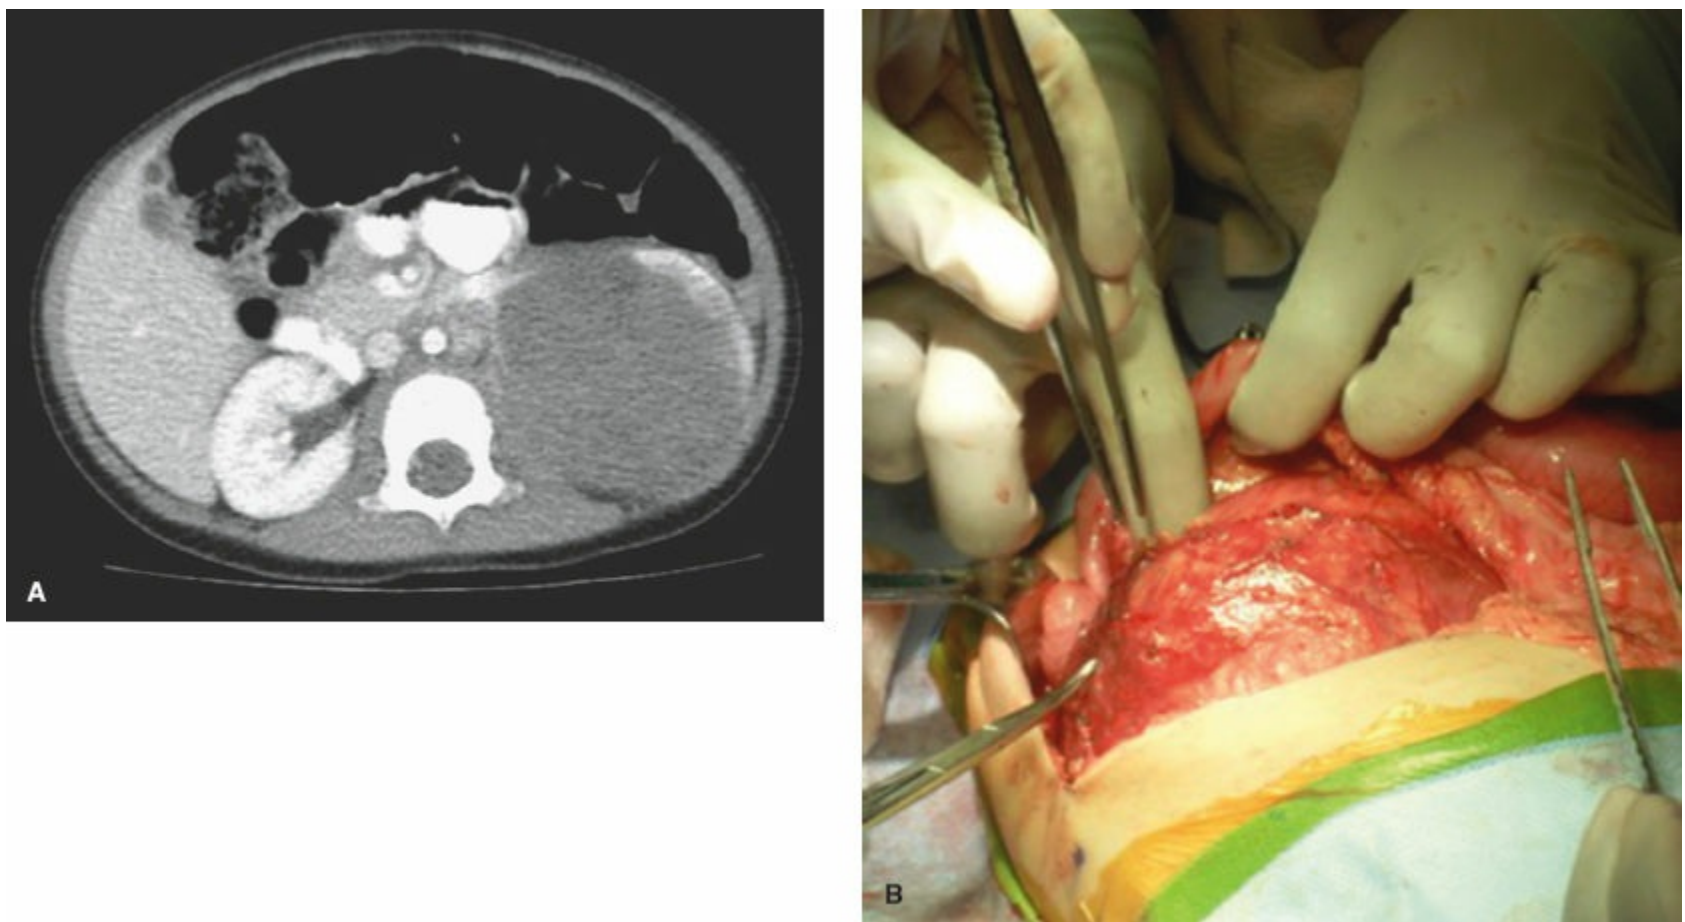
A: Abdominal CT scan with left Wilms tumor displacing midline organs and vessels, rim of kidney enhancing at lateral border. B: Intraoperative view of right Wilms tumor arising from retroperitoneum, displacing colon and midline structures, approached via a generous right supraumbilical transverse abdominal incision.
